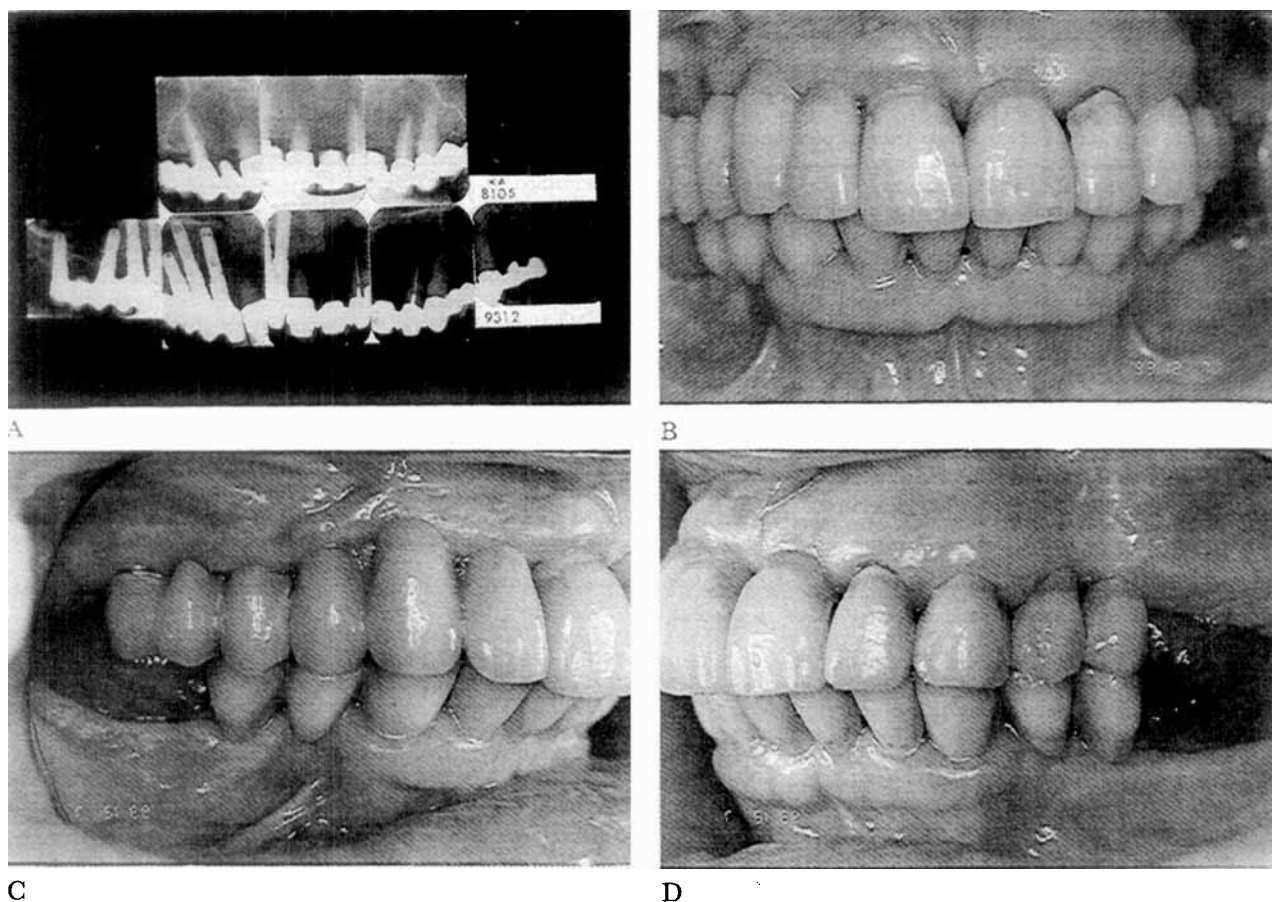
Radiographs (2A) of a fixed partial denture showing the situation in 1981 and in 1993. Tooth 13 was extracted because of a root fracture, and the FPD was hemisectioned. After healing, four implants were placed in the first quadrant to serve as abutments for an implant-supported bridge reconstruction extending from 16 to 12. 2B–D. Clinical view at the follow-up (1993).
